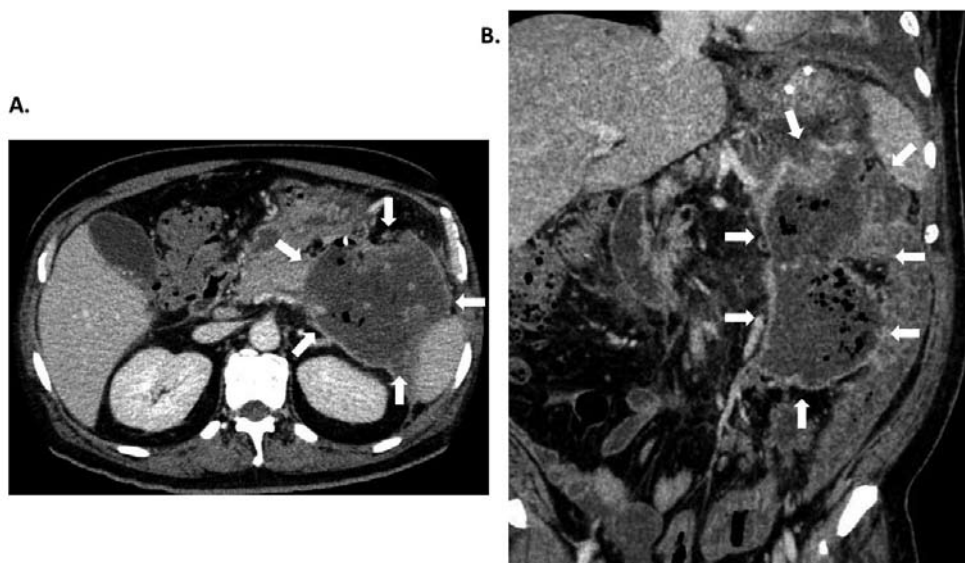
A) Contrast-enhanced CT axial and B) coronal scans showed a hypodense focal lesion with internal septations in the pancreas tail, resulting in a focal contour bulge.
